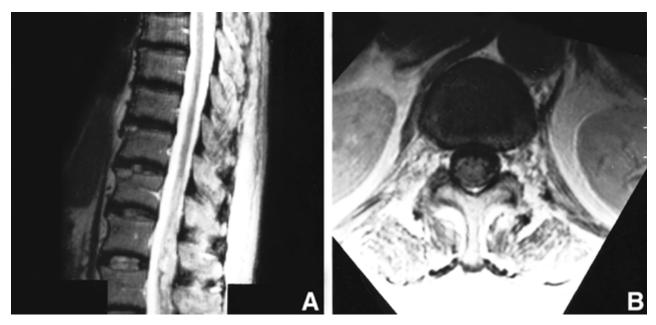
Follow up spinal MRI. (A) T2-weighted sagittal image shows unchanged linear high signal intensity in T11-L2. (B) enhanced T1 axial imageat the level of L1, the lesion still involved mainly gray matter showing no significant enhancement accompained with marked back muscle atrophy.
